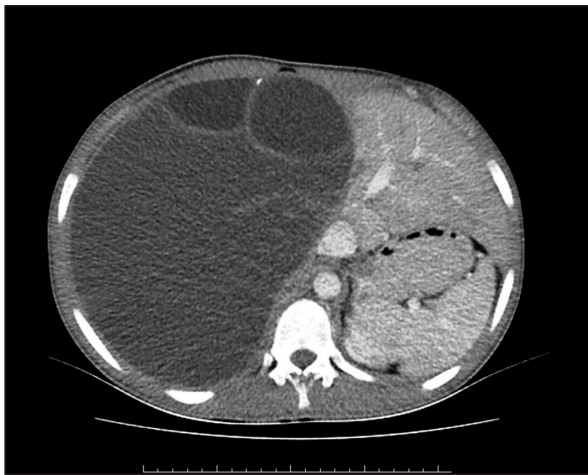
CT scan, the mass in liver with hydatid cyst.
